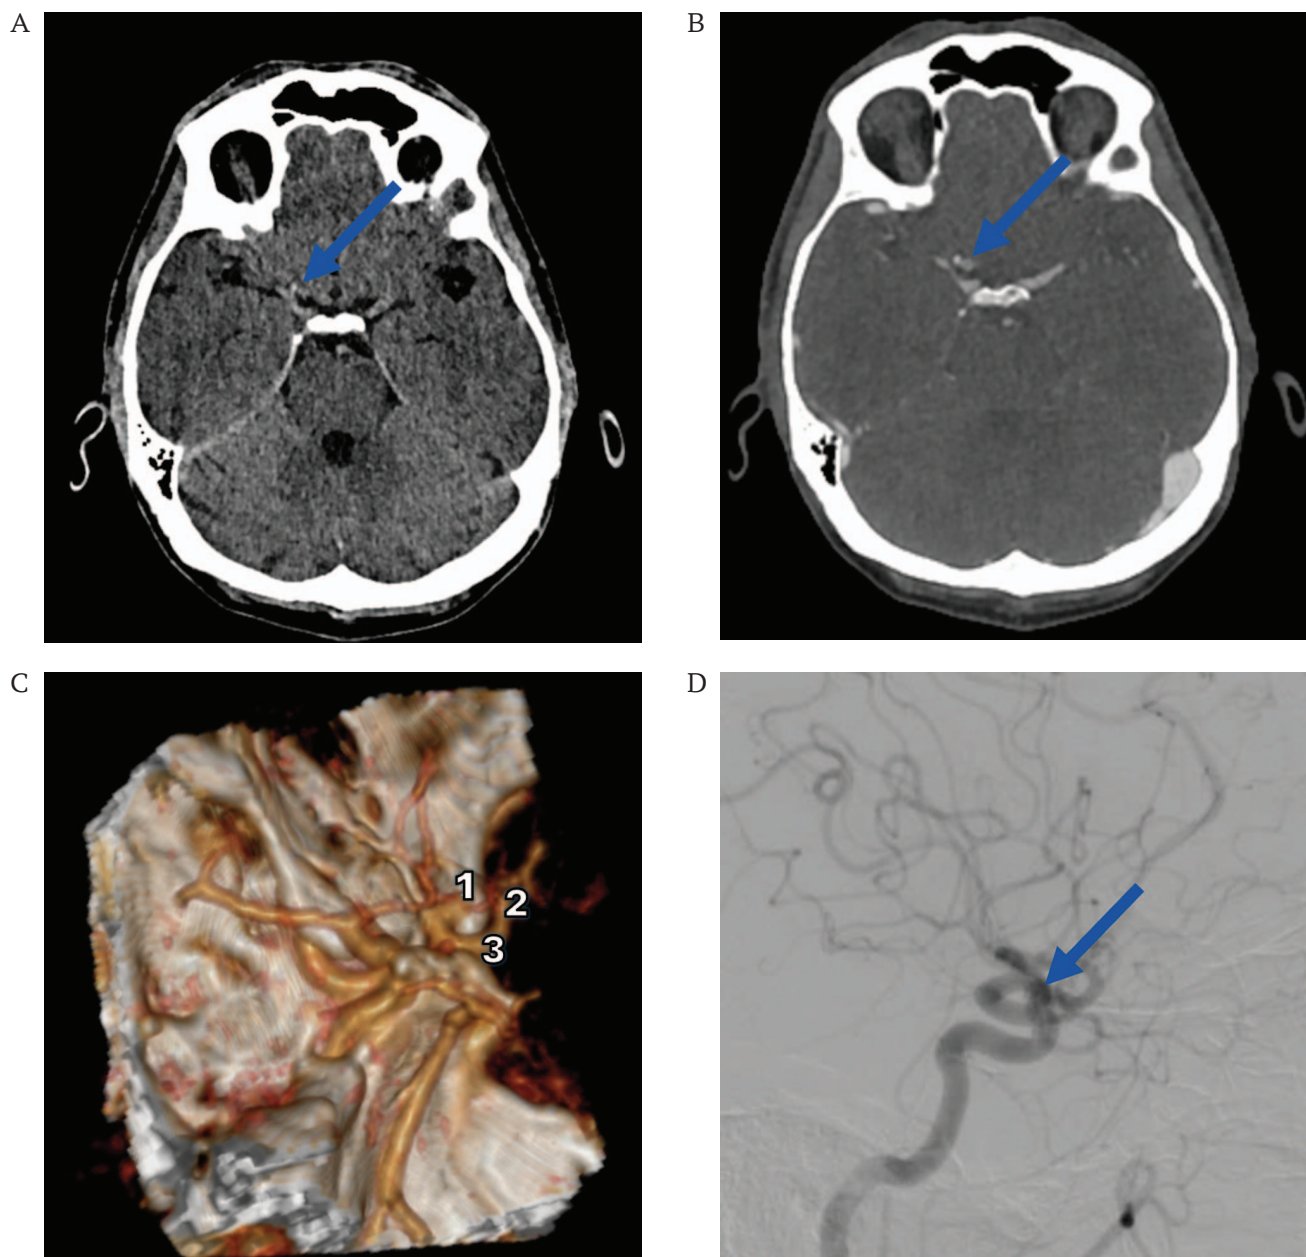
Computed tomography (A), computed tomography angiography (B, C), and cerebral angiography (D) of a 46-year-old patient with an aneurysm of the ophthalmic artery orifice before surgery.
